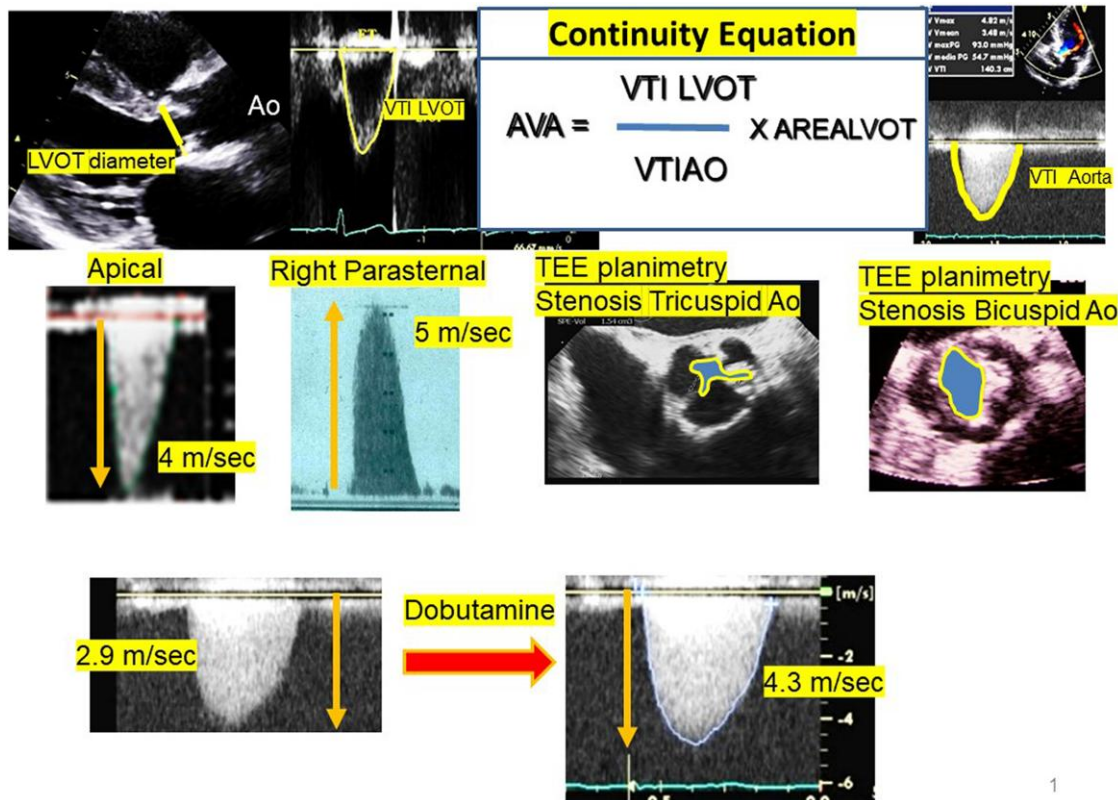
Main measurements, calculations, and formulas for estimating the severity of aortic stenosis. Top: Formula of the continuity equation. Centre: Doppler calculations of the valve gradient and echocardiographic planimetries. Bottom: Example of the aortic gradient at baseline and after the Dobutamine test. LVOT, left ventricular outflow tract; AVA, aortic valve area; VTI, velocity-time integral; TEE, transoesophageal echocardiography; Ao, aortic valve.
